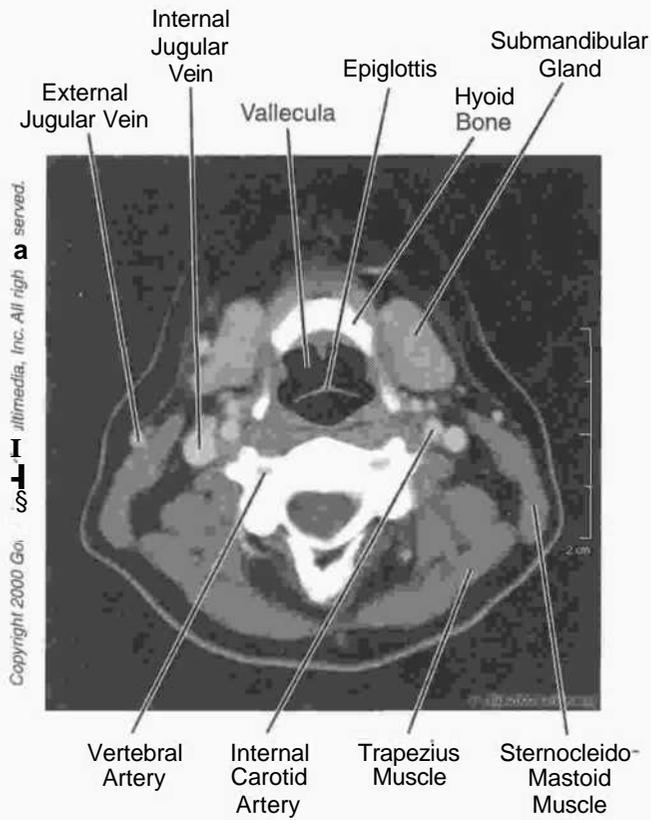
Head and Neck: CT, Neck at C₃
